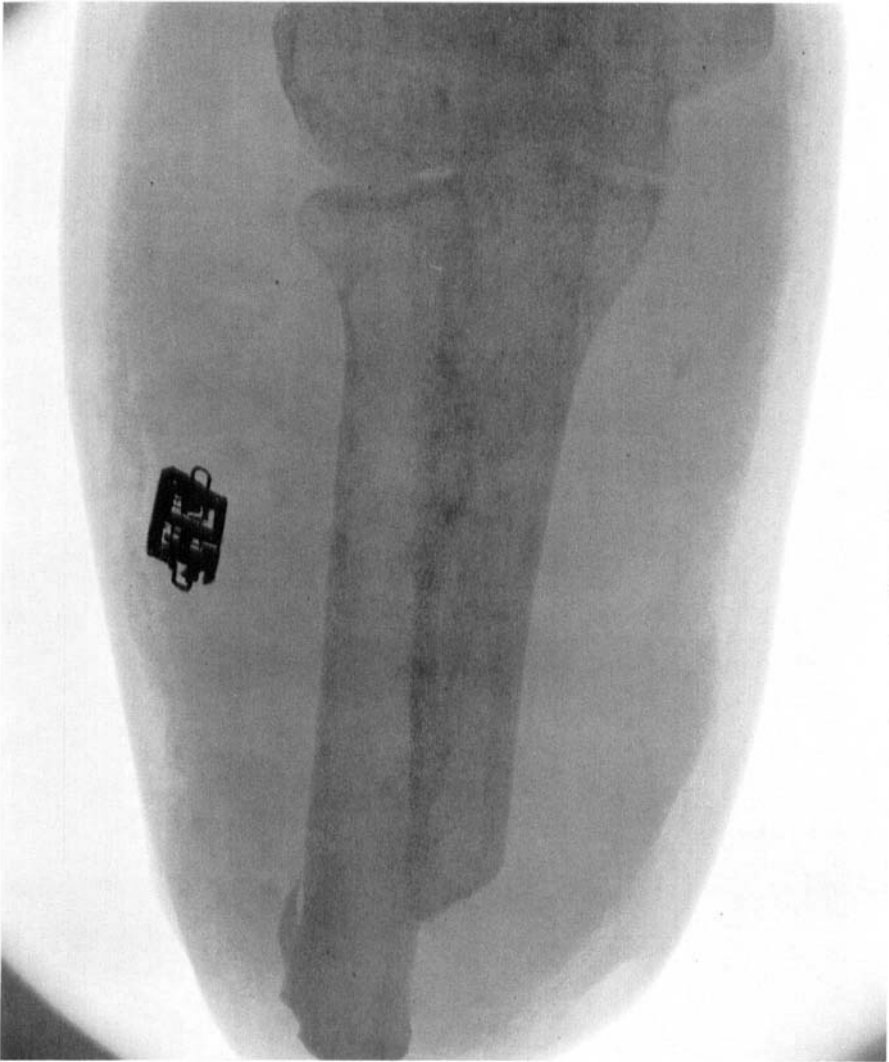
X-ray picture of the implanted aggregate in the patient.
